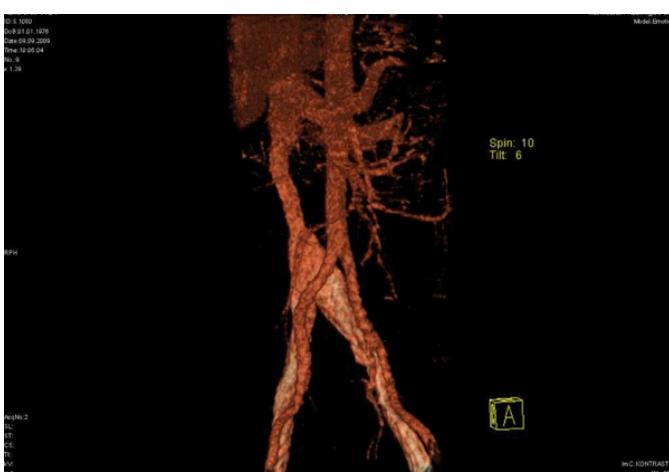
Angio computed tomography and graft in the inferior vena cava.
